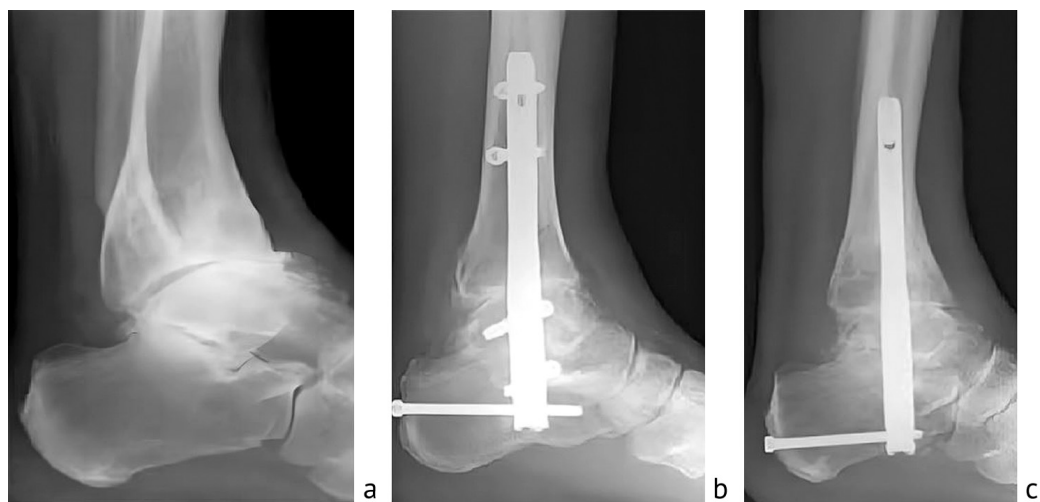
Lateral radiographs of the right ankle joint in a 58-year-old patient; dynamics of the arthrodesis process with internal fixation and a retrograde locking screw: before surgery (a); 3rd day after surgery (b); 3rd month after surgery (c)
